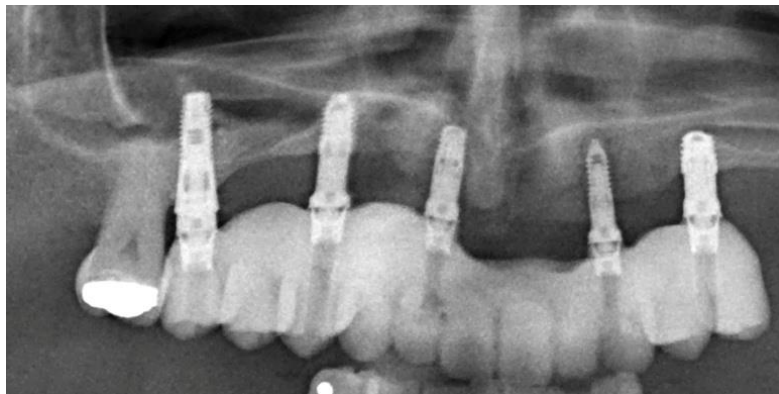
Radiographic image at 5-year follow-up, where the severe bone atrophy can be observed in greater detail, which has been resolved with short and narrow implants, as well as their stability over time despite the the high crown-to-implant ratio
